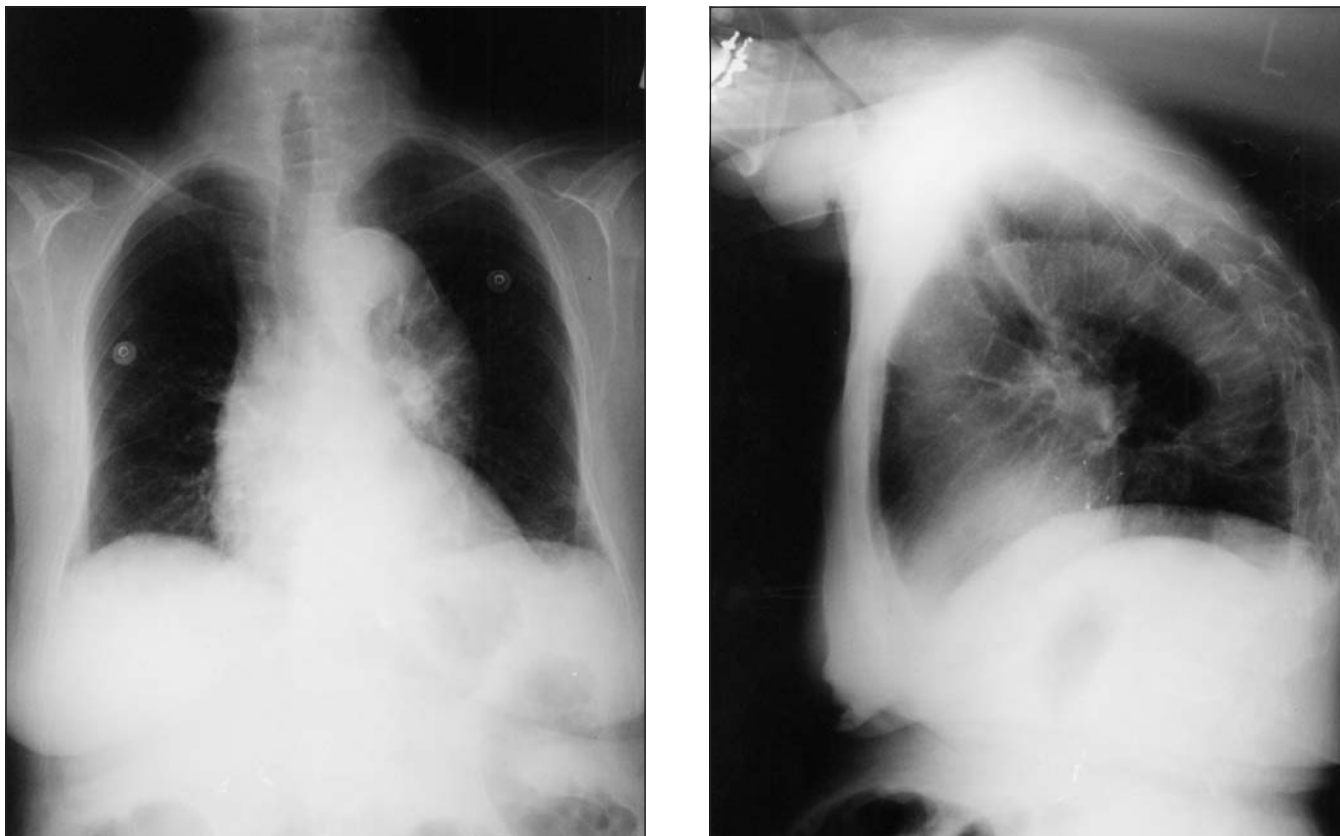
Chest roentgenogram of a 79-year-old female patient. Left Posterior-anterior view. Right Lateral view
